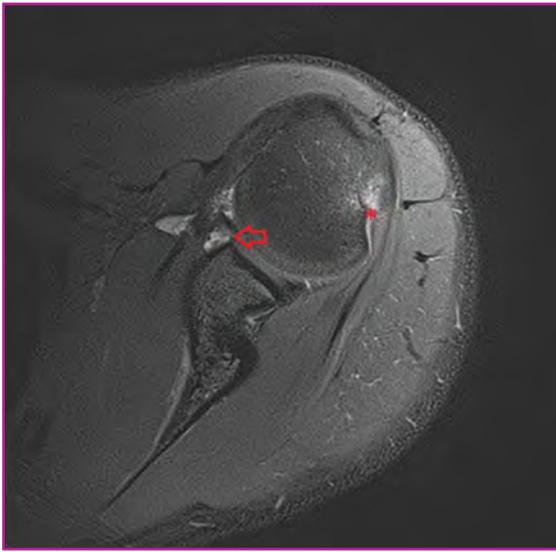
Axillary T2-weighted magnetic resonance imaging, showing the Bankart lesion, an anterior-inferior labrum tear (red arrow). A moderate Hill-Sachs lesion is also present (red asterisk).
